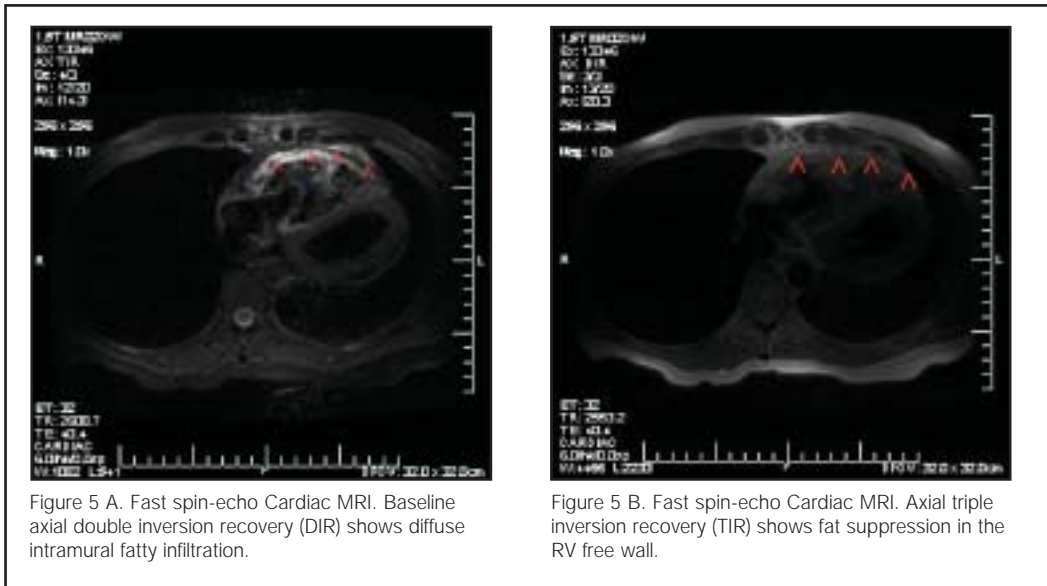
A and 5 B show Freda's fast spin-echo Cardiac MRI.
